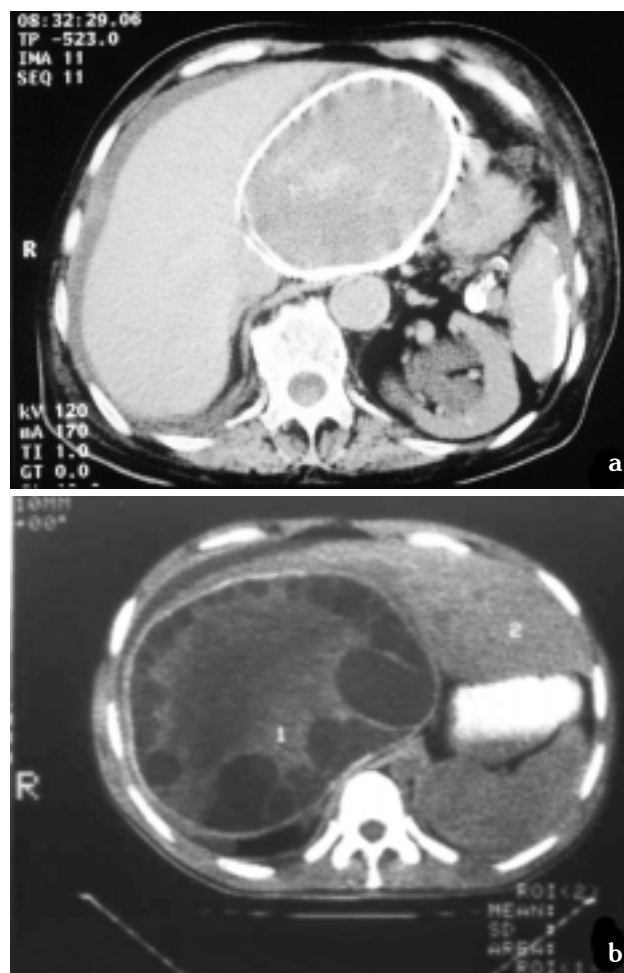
Typical computed tomography findings in hepatic hydatidosis. (a) Monolocular cyst with calcified pericyst. (b) Multilocular hydatid cyst.
